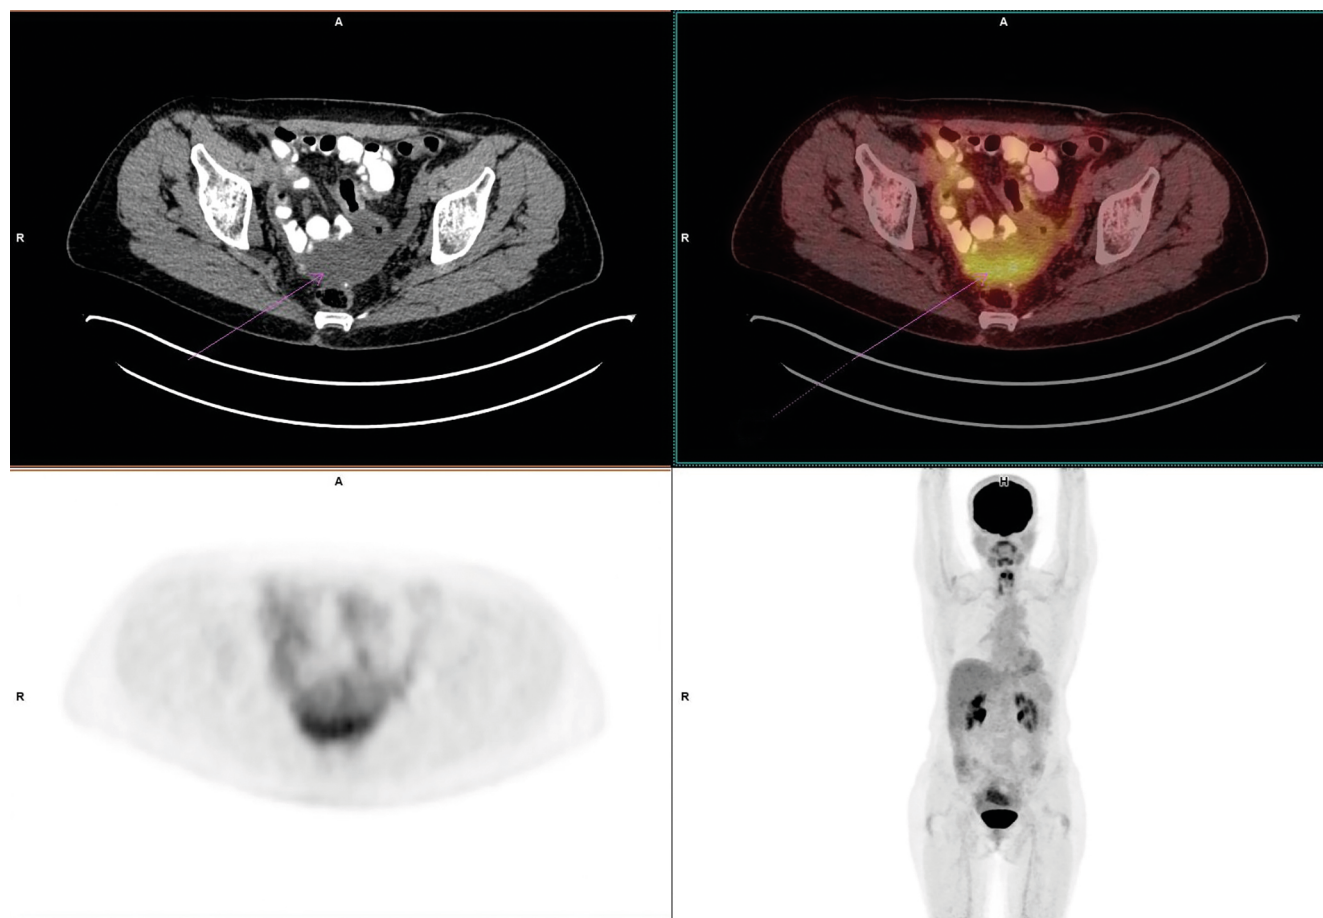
Axial CT and axial fused [^{18}F]FDG PET/CT images (upper row), [^{18}F]FDG PET/CT axial and coronal whole-body maximum intensity projection images (lower row). Malignant ascites (arrow) as the only site of recurrence detected in [^{18}F]FDG PET/CT. The [^{18}F]FDG PET/CT was performed due to an elevated Ca 125 level (467 mL/IU)
